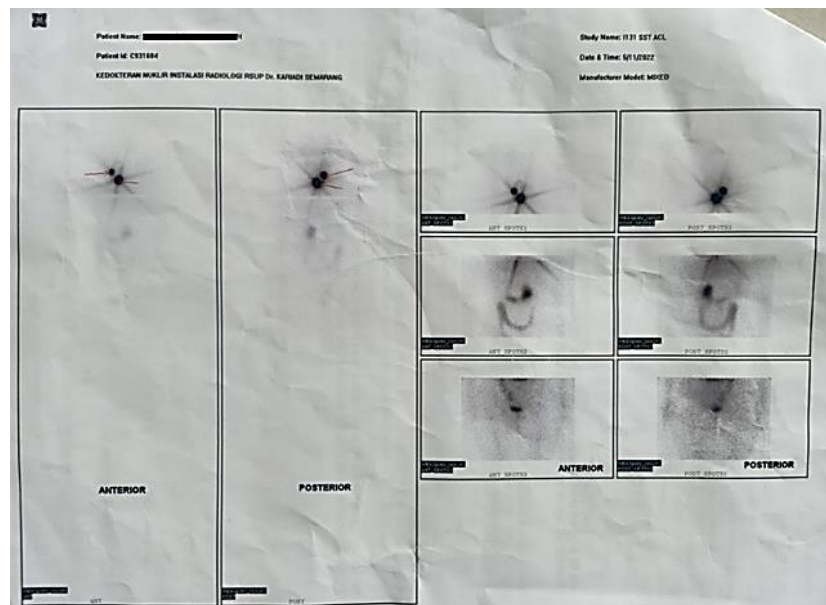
Whole-body scintigraphy imaging following administration of Iodine-131 ablation therapy indicated functional thyroid tissue remnants in the right thyroid field and thyroid tissue metastases in the left supraclavicular area
